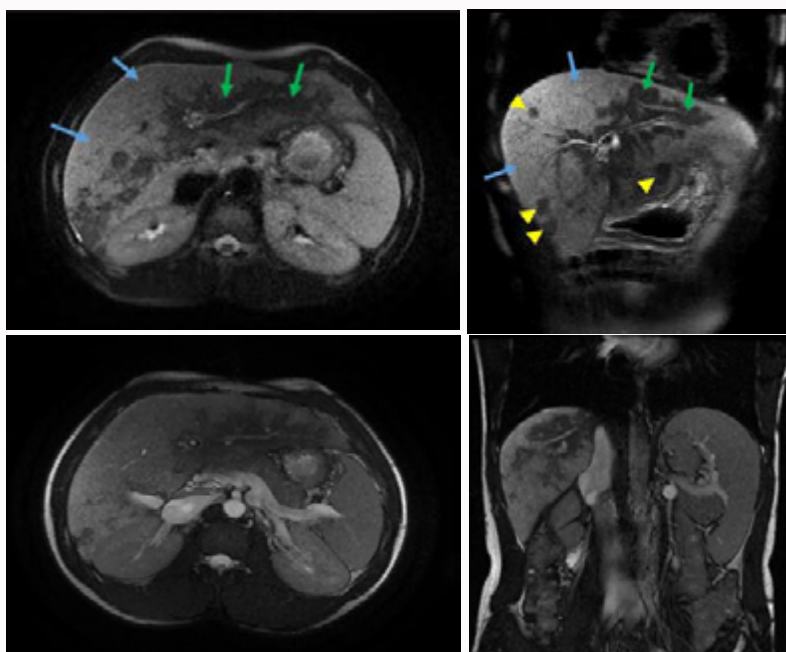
(A-D): MR imaging appearance in patient with CHF. A) Axial T2-weighted images of the liver show diffuse hyperintense fibrotic reticulations (blue arrows) predominantly at peripheral areas. Spared liver parenchyma is visualized at perivascular area (green arrows). B) Coronal T2-weighted images of the liver show diffuse hyperintense fibrotic reticulations (blue arrows) and spared liver parenchyma at perivascular area (green arrows). Also note variable-sized predominantly hypointense regenerative nodules (yellow arrowheads). C-D) Radiological features of portal hypertension in patient with cirrhosis. Axial and coronal 2D Fast Imaging Employing Steady-State Acquisition (FIESTA) show splenomegaly, dilated splenic, left renal and inferior cava veins.
